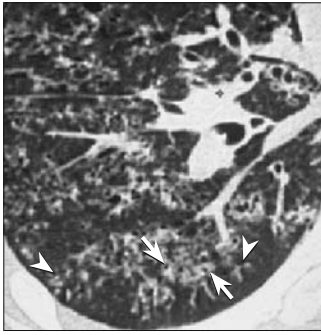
Postprimary tuberculosis. CT image of the lungs demonstrates bronchiolar wall thickening (arrows) and mucoid impaction of contiguous branching bronchioles producing a tree-in-bud appearance (arrowheads). Tree-in-bud is characteristic, but not pathognomonic, for tuberculosis. Reprinted with permission from *Radiographics* (1).
